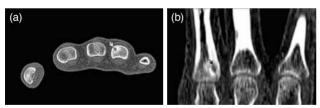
Computed tomography scan in the (a) axial (b) sagittal plane shows a thypical nidus (arrow) in the dorsal aspect of the phalanx.
